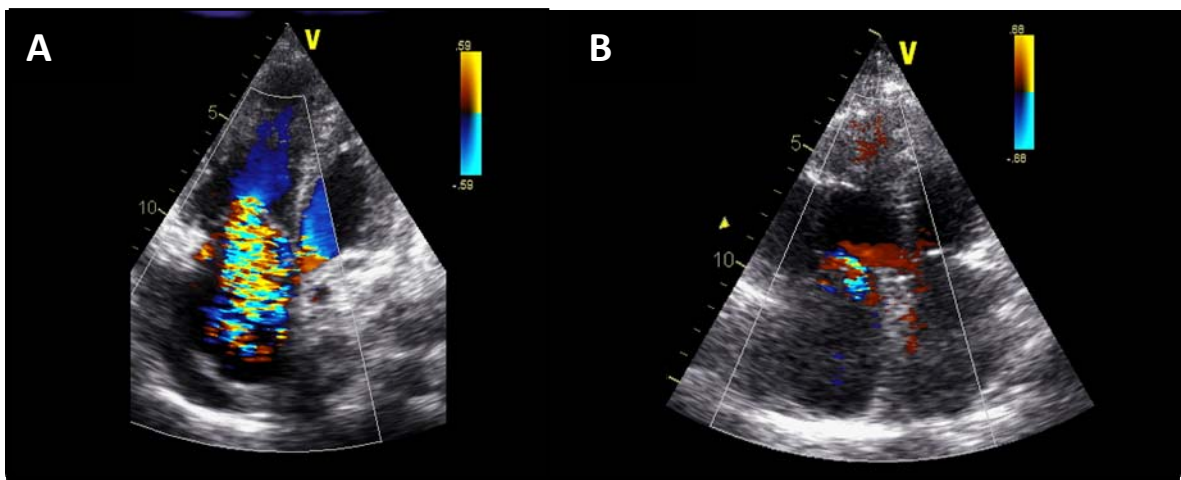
3D echocardiography can be utilized to interrogate the TV apparatus of diseased patients. Regurgitation jets can be visualized in the four chamber view and are seen above in patients with severe pulmonary hypertension, with severe (A) and moderate (B) TR jets (click image A for video).
